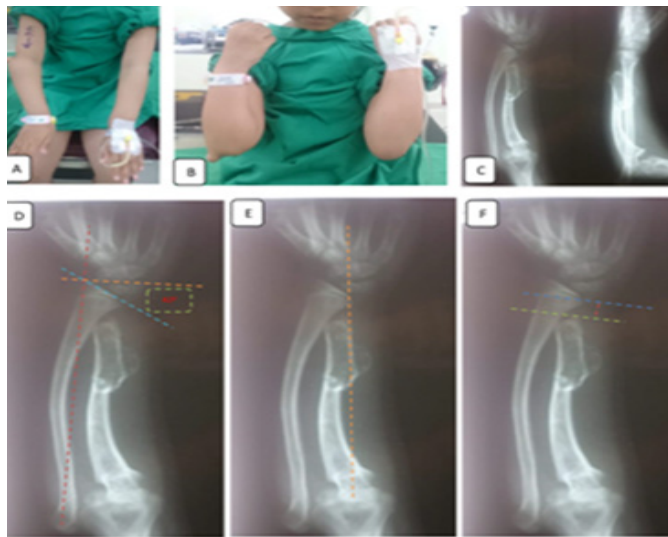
(a) limitation in the pronation of the right elbow (range of motion $0-50^\circ$) with prominence over the lateral aspect of the left elbow and ulnar deviation of the wrist (b) Pre-operative picture showing limited flexion of the right elbow (range of motion $10-110^\circ$) (c) Plain radiograph of radius and ulnar with ulnar minus deformity of the wrist, distal ulnar exostoses and anterolateral radio-capitellar dislocation (Masada type IIB deformity). These radiographs showed the radiographic measurements: (d) The radial articular angle (RAA) was 42° which defined as the angle between a line running along the articular surface of the radius (blue line) and another line (orange line) that was perpendicular to a line (red line) joining the centre of the radial head to the radial border of the distal radial epiphysis (the radial styloid in skeletally mature patients). (e) Carpal slip was abnormal with ulnar displacement of the lunate more than 50%. It was measured by determining the percentage of the lunate that was in contact with the radius. First, a line was drawn from the centre of the olecranon through the ulnar border of the radial epiphysis (radial articular surface in mature patients). This line normally bisects the lunate. (f) Red line represented the ulnar variance. It was measured from the distal ulnar tip to the ulnar border of the distal radial epiphysis. This patient had -35 mm
